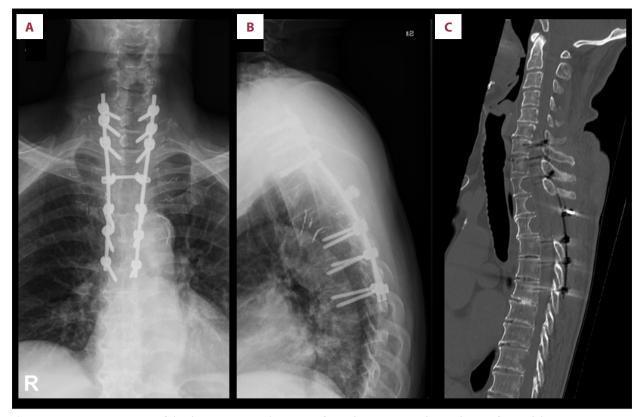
Postoperative images of the thoracic spine with posterior fusion between C7 and T7 and circumferential decompression at T2-4. (A) A posteroanterior radiograph. (B) A lateral radiograph. (C) A sagittal computed tomography (CT) image showing sufficient decompression at T2-4.
